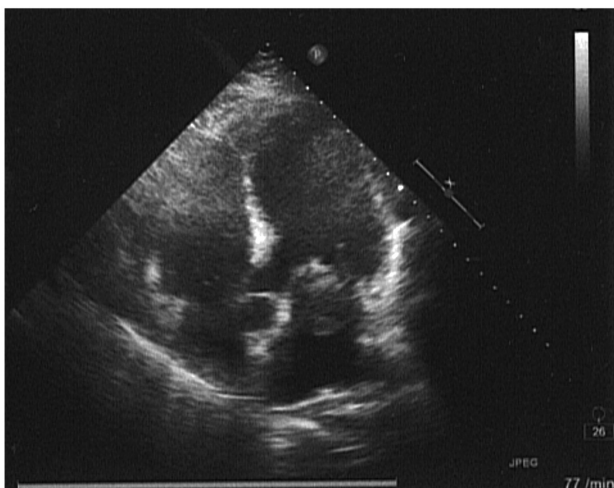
Transthoracic view of the tumor in the left atrium.
